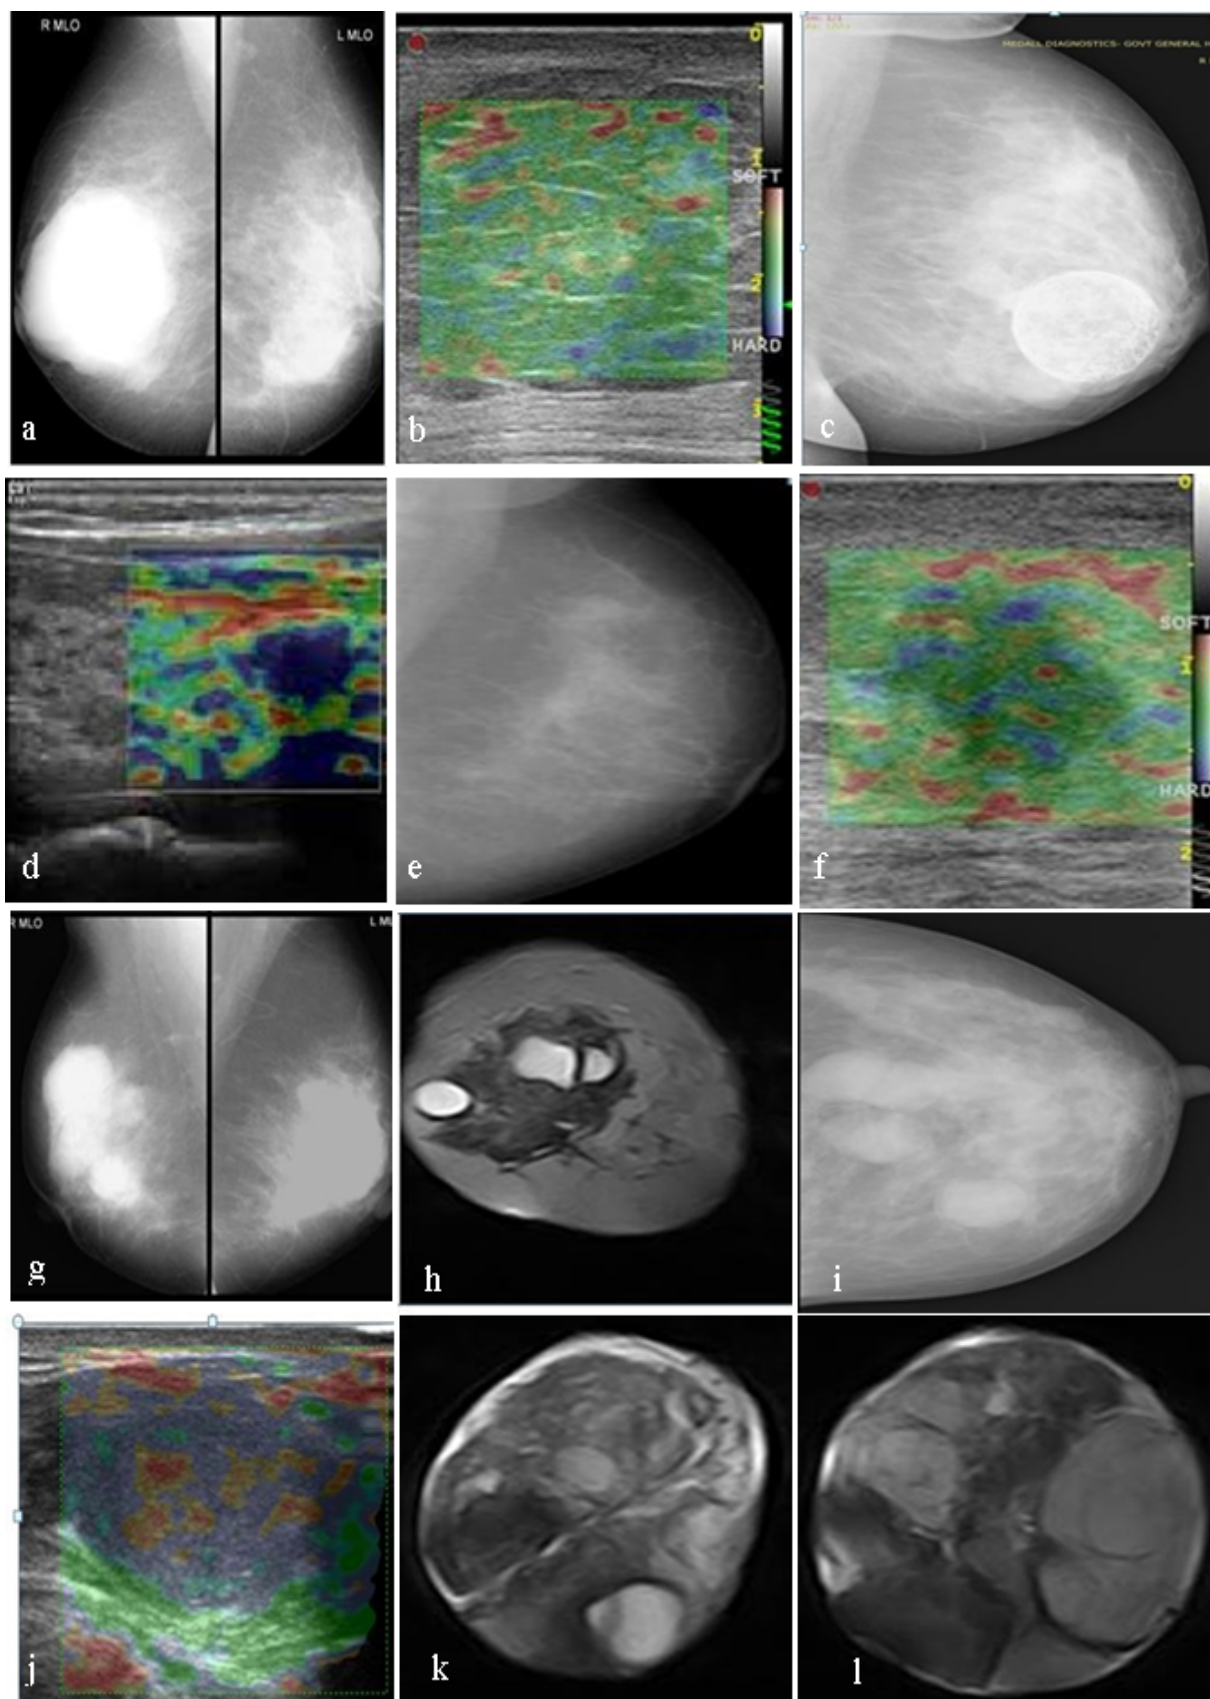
a. Giant fibroadenoma -RT and LT MLO, b. Giant fibroadenoma -B mode US, c. Oilcyst –MLO view, d. Oilcyst –UE. e. DCIS-LT MLO, f. DCIS-LT UE, g. Fibrocystic disease -RT MLO and LT MLO, h. Fibrocystic disease -T2W MRI. i. Multiple fibroadenomas- LT CC. j. Multiple fibroadenomas –UE, k. Multiple fibroadenomas-T2W MRI, l. Multiple fibroadenomas-T1W MRI.
